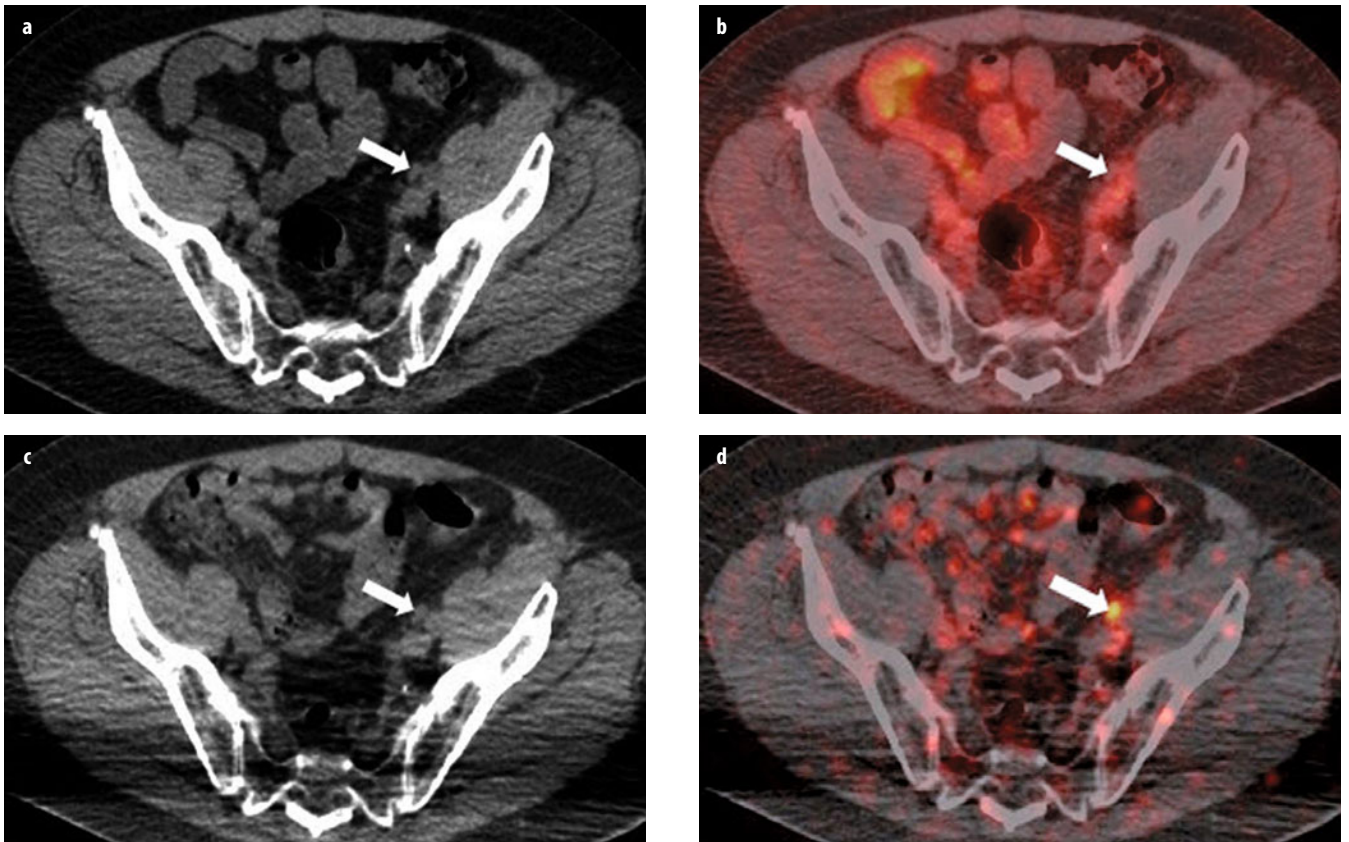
a-d. a Axial computed tomography (CT) and b fused [^{18}F]-fluorodeoxyglucose (FDG) positron emission tomography computed tomography (PET/CT) images in a patient with prior prostatectomy for Gleason score 4+3 cancer undergoing evaluation for metastatic prostate cancer demonstrate a subcentimeter left external iliac lymph node without abnormal FDG uptake. c Axial CT and d fused zirconium 89 [^{89}Zr]-J591 PET/CT performed 8 days later demonstrate no change in size but abnormal J591 uptake in the same left external iliac lymph node. Fine-needle-aspiration biopsy confirmed the presence of metastatic prostate adenocarcinoma
